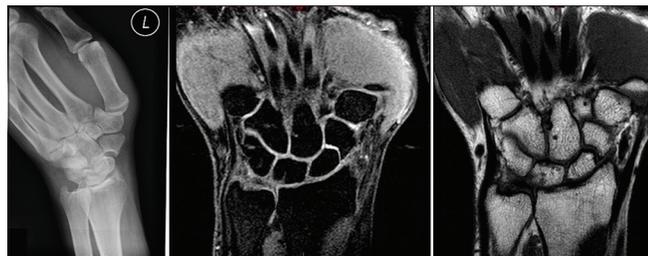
Posteroanterior view plain radiographs demonstrating chronic non-union of the waist of the left scaphoid with sclerotic edges and complementary T1- and T2-weighted magnetic resonance image.
